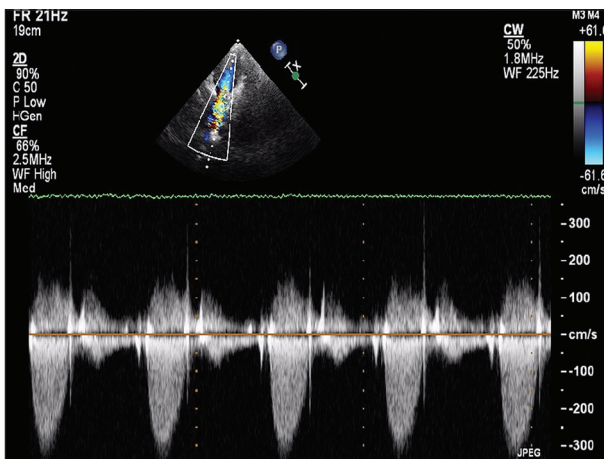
Echocardiography in apical 4-chamber view with color Doppler and continuous wave showed severe left AV valve regurgitation with Tricuspid regurgitation velocity up 6 meter/second
